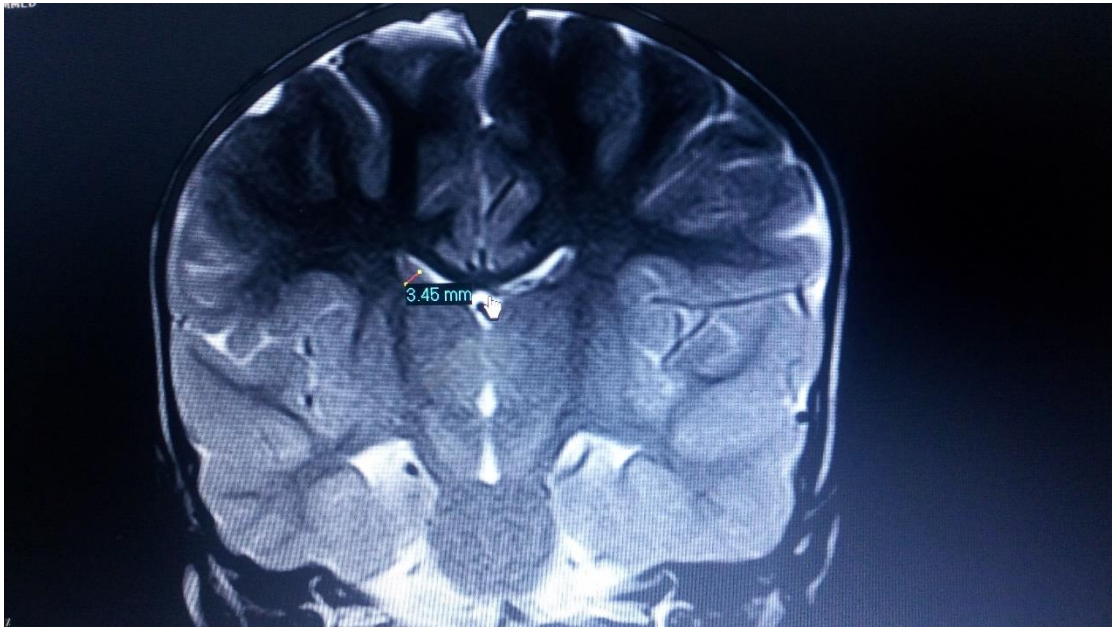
Coronal T2 MRI Brain (tail of caudate nucleus)
